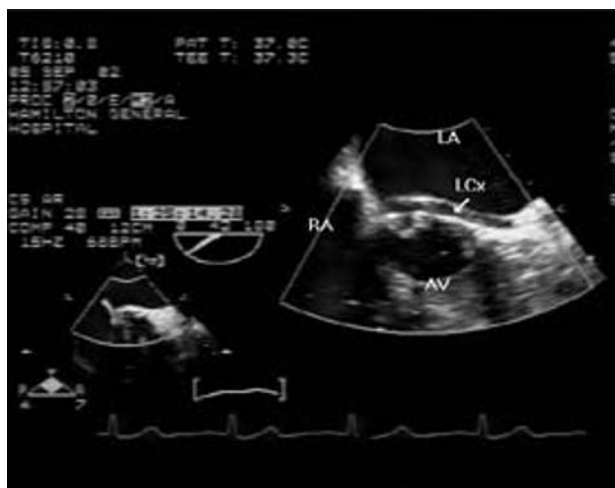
Intraoperative transesophageal echocardiogram image of the anomalous left circumflex artery (LCx). Left atrium (LA), right atrium (RA), aortic valve (AV).
